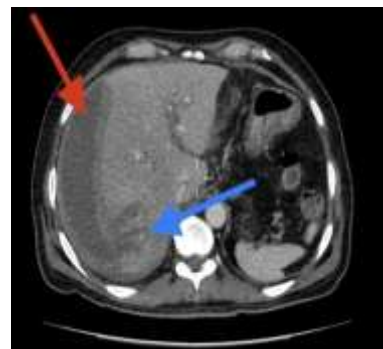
Axial slice of post contrast CT abdomen showing hepatic sub capsular hematoma as shown by red arrow and hepatic lacerations as shown by blue arrow.
